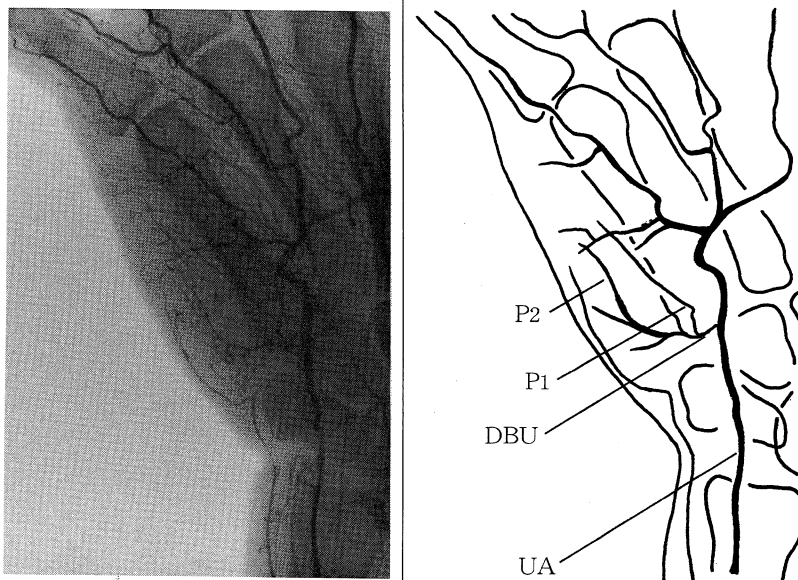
X-ray finding of the hypothenar region. UA : Ulnar artery, DBU : Deep palmar branch, P₁, P₂ : Skin perforator
